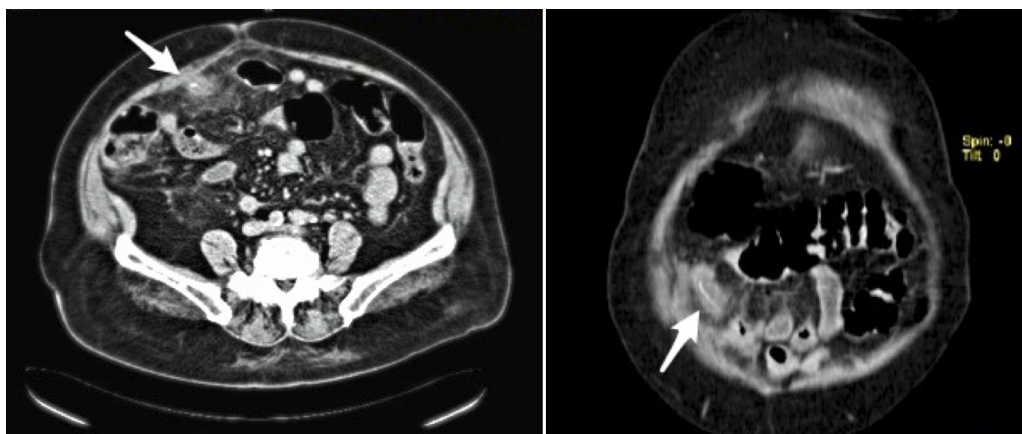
Axial and sagittal slides of abdominal CT scan. It is visible an undefined liquid collection involving a linear image suggestive of foreign body (arrows).
